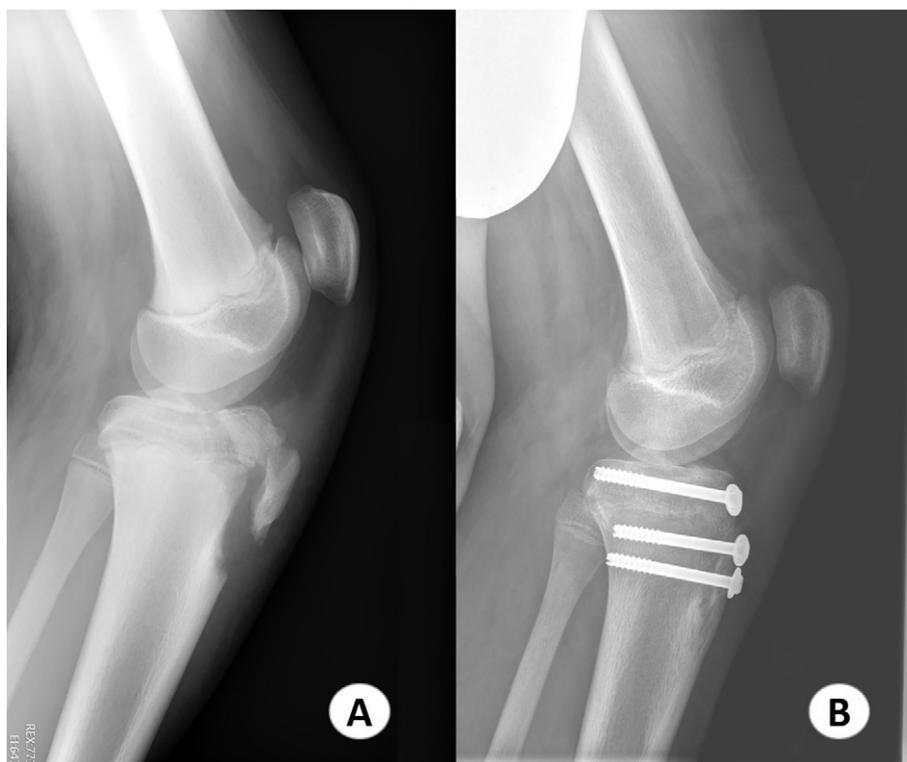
A) Preoperative lateral X-ray knee shows tibial tubercle fracture type IIIB. B) Follow-up X-ray after open reduction and internal fixation using cannulated screws.
